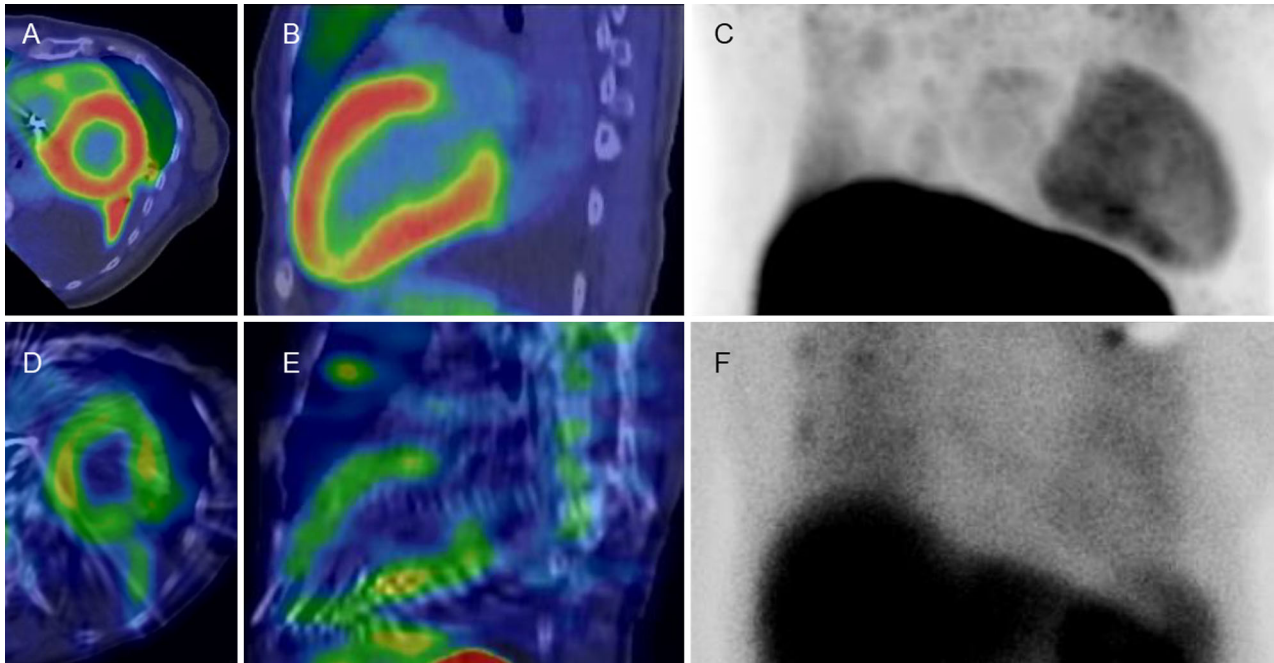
Patient No. 2. ^{11}C -PIB PET/CT; A short, B vertical long, C MIP image, $^{99\text{m}}\text{Tc}$ -aprotinin scintigraphy; D short, E vertical long, F Planer image. Both ^{11}C -PIB and $^{99\text{m}}\text{Tc}$ -Aprotinin imaging showed intense uptake at the entire left ventricle wall. AL-type amyloid deposition was proved by cardiac biopsy. Patient had a poor prognosis with progressing serious heart failure within 2 months.
